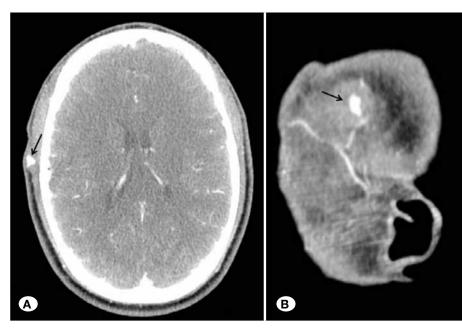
A) The CT-angiogram of the pseudoaneurysm in the right temporal extracranial area on axial image (black arrow). B) The CT-angiogram of the pseudoaneurysm located on the parietal brunch of the right superficial temporal artery on sagittal image (black arrow).
